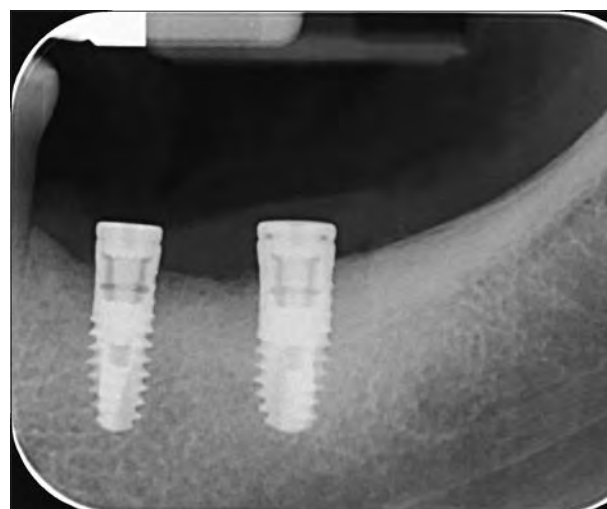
Endoral control X-ray after surgery.
